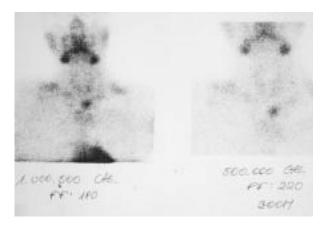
Technetium-cardiolite scintigraphic and ultrasound studies of P1. After injection of 550 Mbq 99m-Tc-cardiolite, a pathological enhancement is seen below the thyroid on the left side of the neck, that is colocalized with a 27x15x18 mm mass found by cervical ultrasound.
